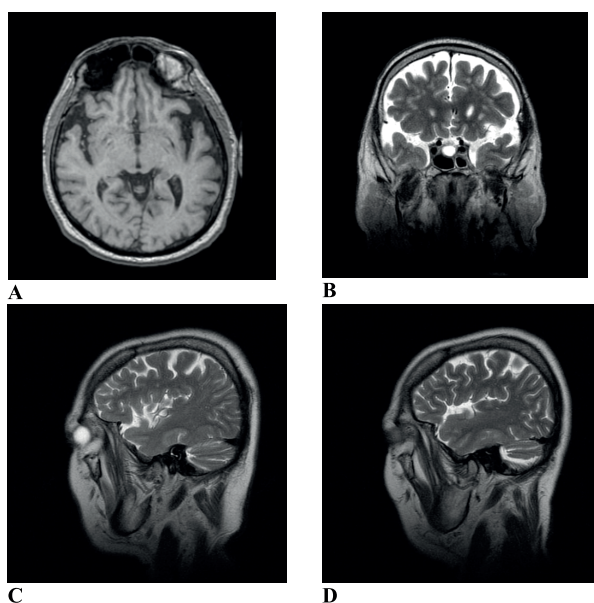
Brain MRI of S.D., 43 year old artist. A – 1 SET sequences, transverse plane. Asymmetrical cortical atrophy in the vicinity of the left temporal lobe. B – FSET2 sequences, frontal plane. Asymmetrical cortical atrophy in the vicinity of the left temporal lobe. C – FSET2 sequences, sagittal plane, left temporal lobe. Cortical atrophy in the left temporal lobe (larger) and in the left frontal lobe (discrete). D – FSET2 sequences, sagittal plane, the temporal lobe. Cortical atrophy in the temporal lobe, right (larger) and the right frontal lobe (discrete)
